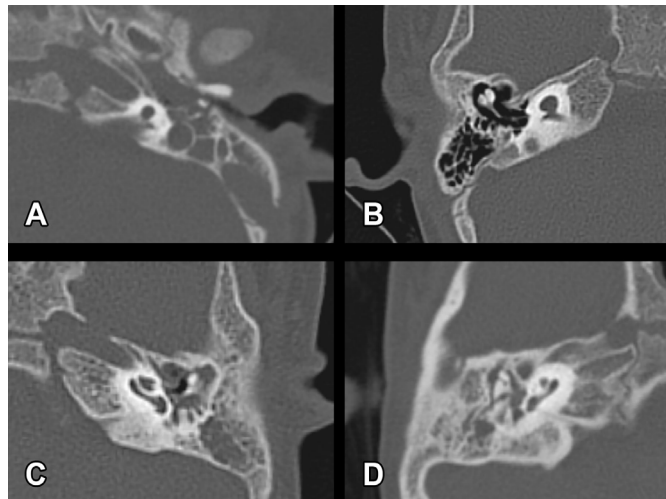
Cochlear hypoplasia subtypes on axial or axial-oblique computed tomography, one ear of each subtype
